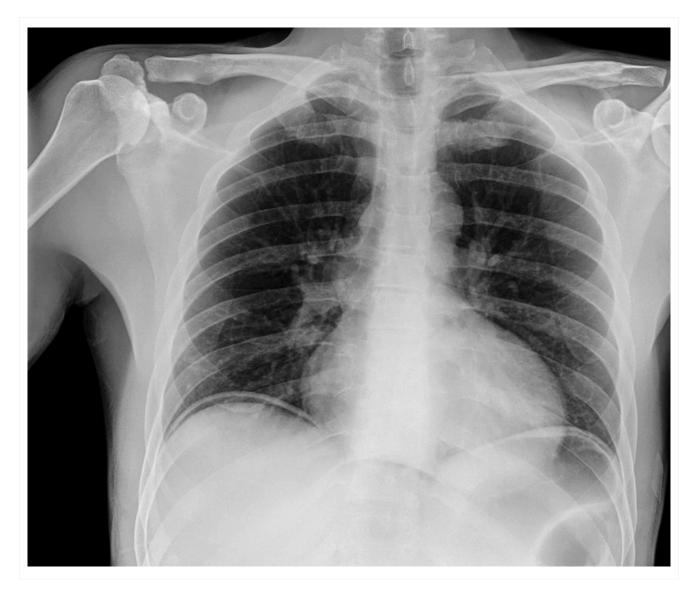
Abdominal free gas pockets, x-ray
